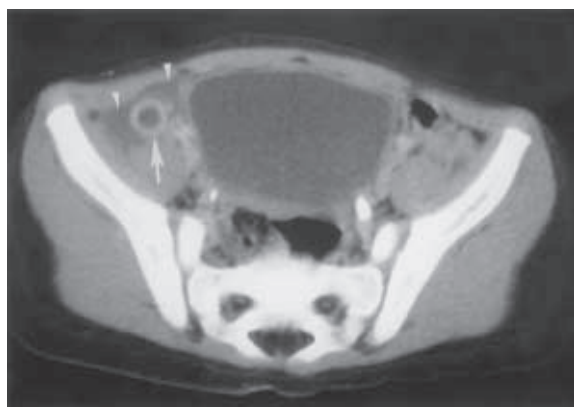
Appendicitis without perforation. On CT, the appendix (arrow) is enlarged with marked enhancement of its wall. Adjacent fluid is seen (arrowheads).
